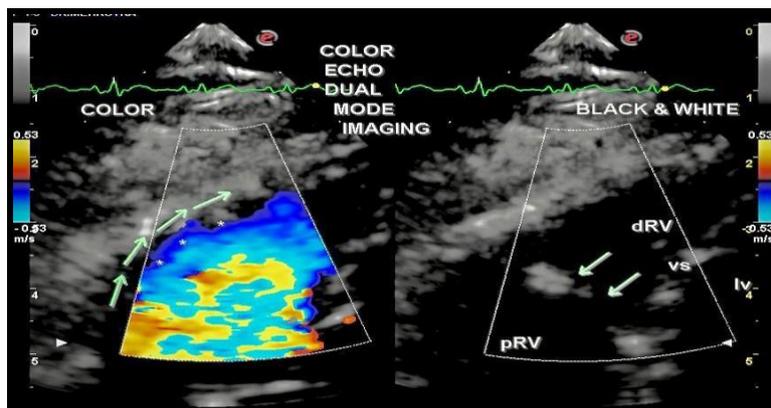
Color Echocardiography- Dual mode imaging.
